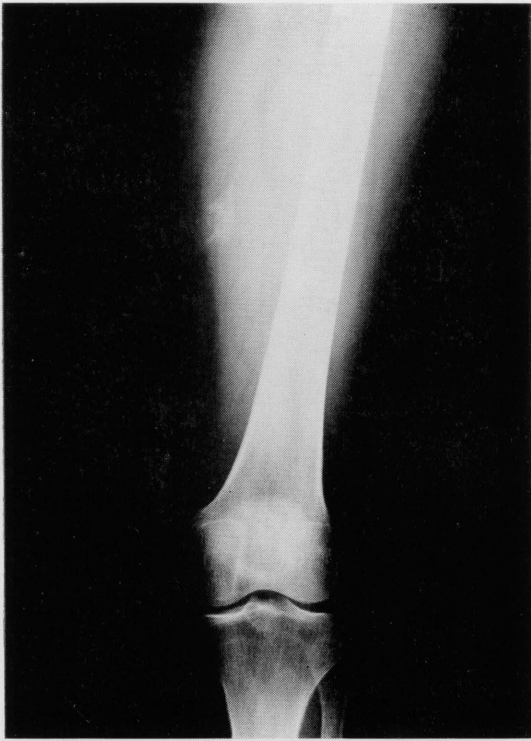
Antero-posterior plain radiograph of the left thigh. There is a large soft tissue mass medial to the femur, with intrinsic calcifications and without underlying osseous involvement.
